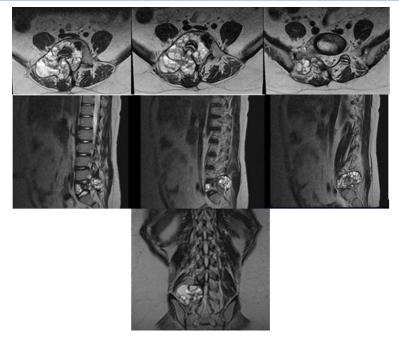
Spine MRI /March 2023-The inhomogeneous mostly high-signal T1 multicystic mass involving the body of L5 on the right with the corresponding peduncle, arch and transverse process persisted. The dimensions in anterior-posterior dimension are about 6.1 cm, transverse 7.8 cm and caudal-cranial 5.1, the advancement being at the expense of the transverse dimension/towards the body medially and to the left. The stenosis of the neuroforamen on the right persists as the corticalis is not disturbed. Conclusion-MRI data for an advancing aneurysmal bone cyst.
